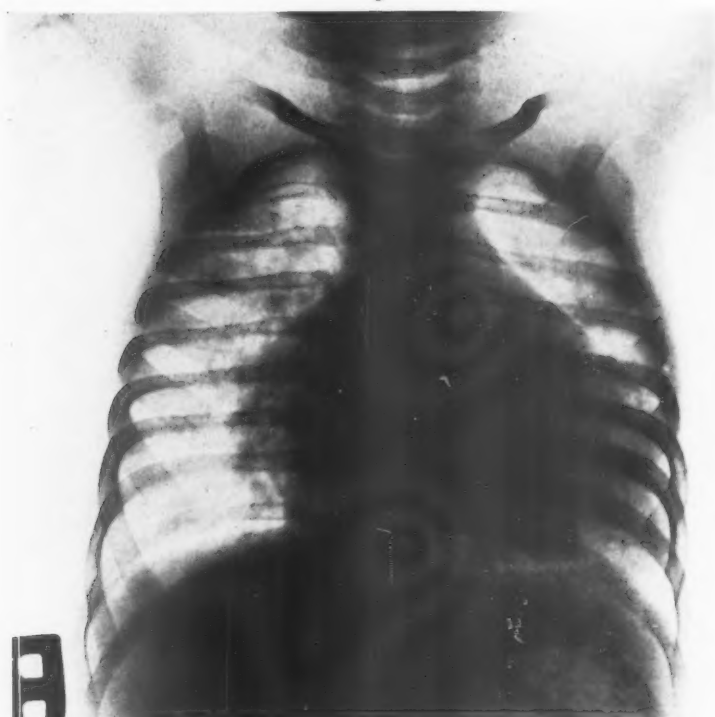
X-ray film of the thorax showing the proportions of the heart.
